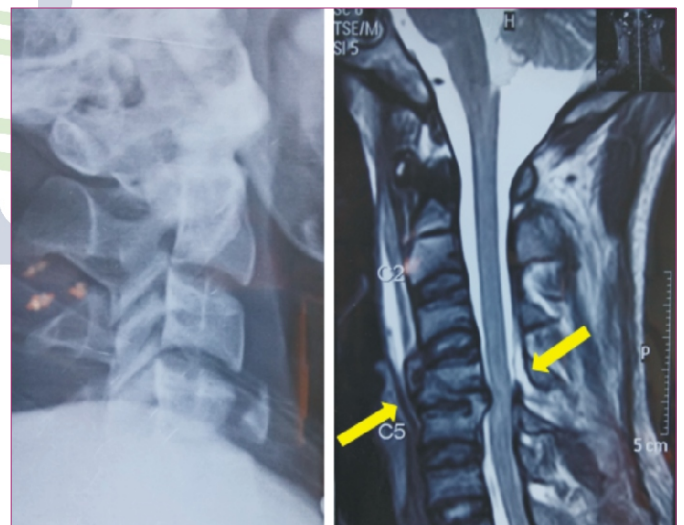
Case example- 22 year old male sustained a RTA, presented with intact neurology. X-ray shows tear drop fracture of vertebral body which seems to be stable. On MRI, evident DLC disruption shown by arrows indicating instability. [SLIC-distraction 3+ intact neurology 0+ DLC disruption 2=5]
